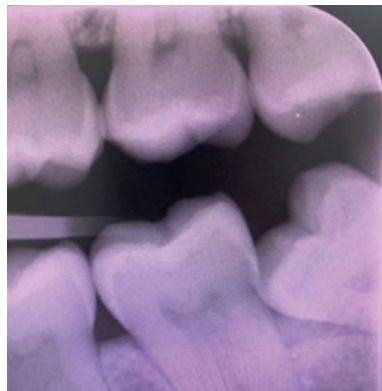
Bitewing radiograph with possible distal radiolucency in second molar with neighbouring mesioangular third molar
